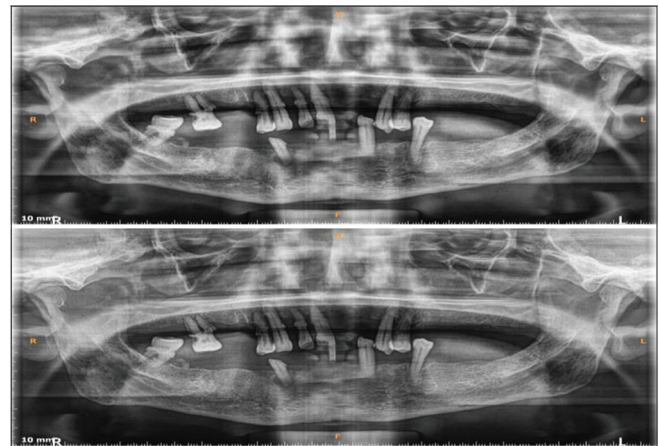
Orthopantomogram
